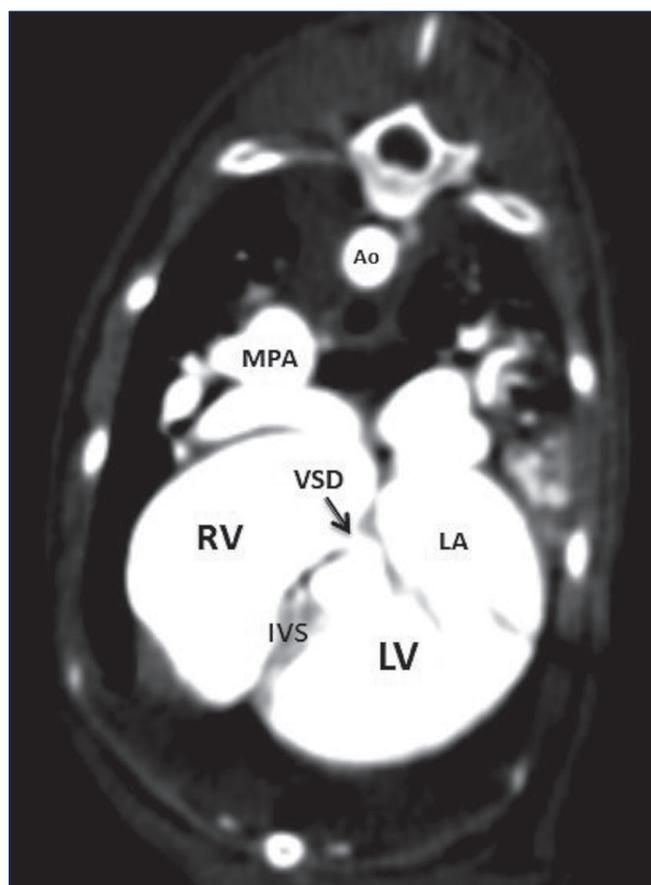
Three-dimensional computed tomographic angiography shows the presence of ventricular septal defect (VSD) just behind the atrioventricular valves between two ventricular chambers
